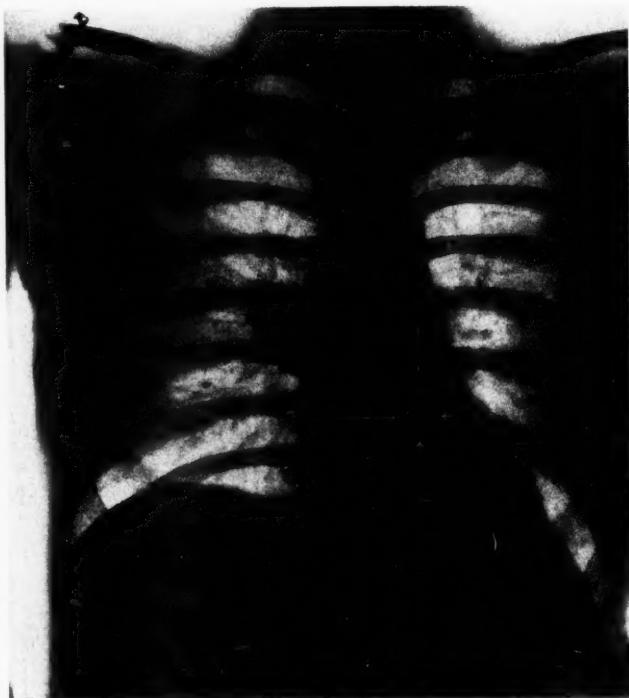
Case III (Fbdy. No. 1054). Roentgenogram of woman aged twenty-seven years, showing pulmonary abscess due to a pencil cap that had been in the lung for twenty-one years. Removed by peroral bronchoscopy under local anesthesia.
